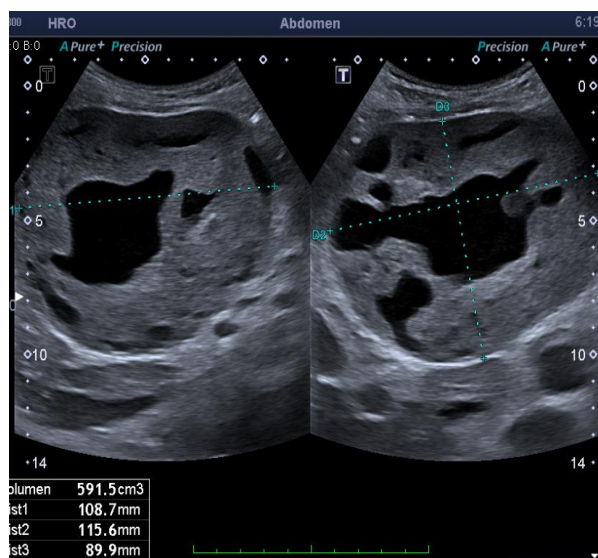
Ultrasound showing an amorphous, heterogeneous image with partially defined edges, with solid characteristics, with anechoic areas inside that correspond to areas of necrosis or cystic degeneration.
